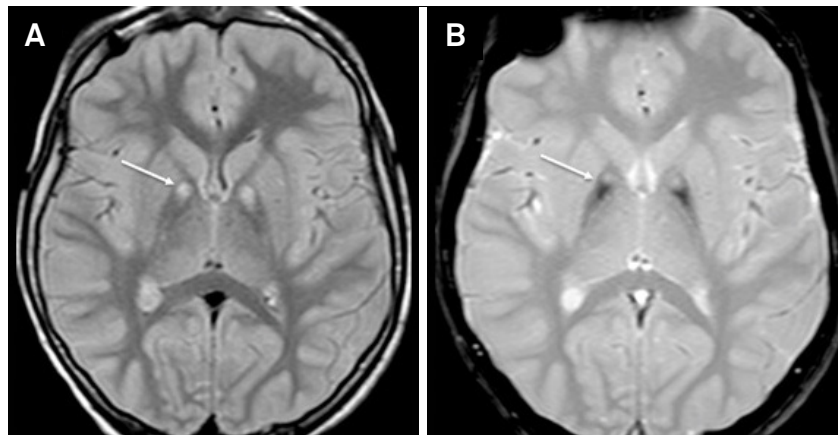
Brain MRI of a patient with pantothenase kinase-associated neurodegeneration (PKAN). Axial FLAIR- (A) and GRE T2-weighted (B) MRI discloses 'eye-of-the-tiger' sign, defined as a medial area of hyperintense signal within an hypointense signal in globus pallidus bilaterally.
